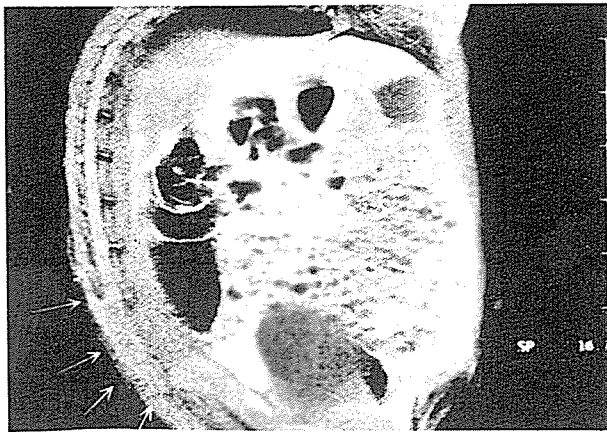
Photograph showing MRI evaluating.
